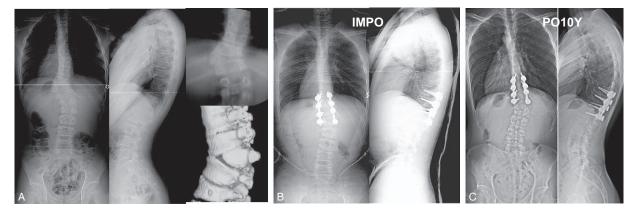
(A) A 12-year-old male who had congenital hemivertebra of T11 with 43° of left thoraco-lumbar main curve. Posterior vertebral column resection and bilateral pedicle screw insertion were performed on both T9 and L1. (B) Immediate postoperative radiographs showed that the main curve improved to 14° . (C) Ten years follow-up radiographs showed that the main curve was changed to 16° .
